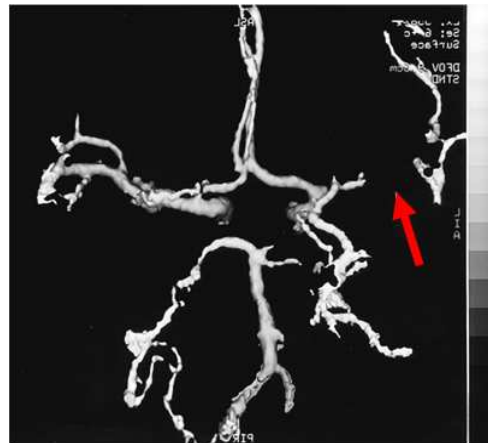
CT angiography displaying MCA occlusion (red arrow) in a stroke patient. Modified from Wong et al (1996)
